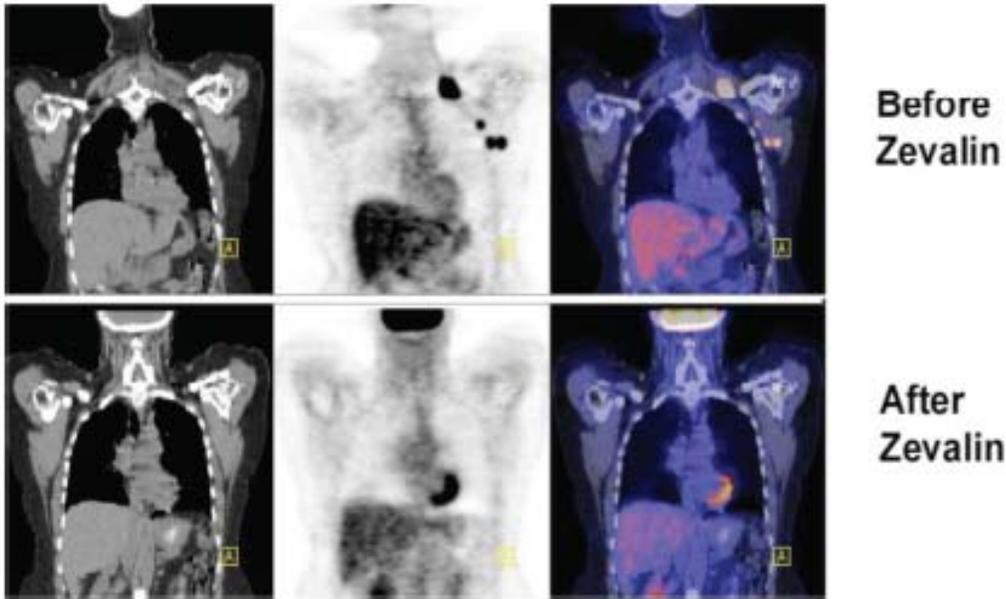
This set of “before and after” PET/CT images demonstrates the use of these nuclear imaging modalities to evaluate the clinical effects of radioimmunotherapy using radiopharmaceutical compounds such as yttrium-90 ibritumomab tiuxetan (Zevalin[®]) in the treatment of malignant lymphoma. SOURCE: Courtesy of Peter Conti, University of Southern California.
